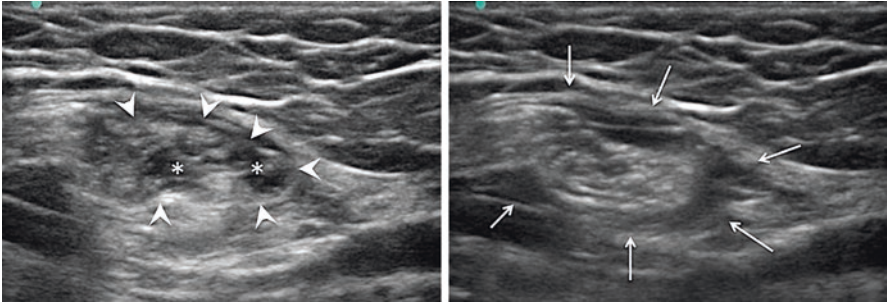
Sonography of inguinal canal and the effect of the injectate. (Reprinted with permission from Philip Peng Educational Series)
